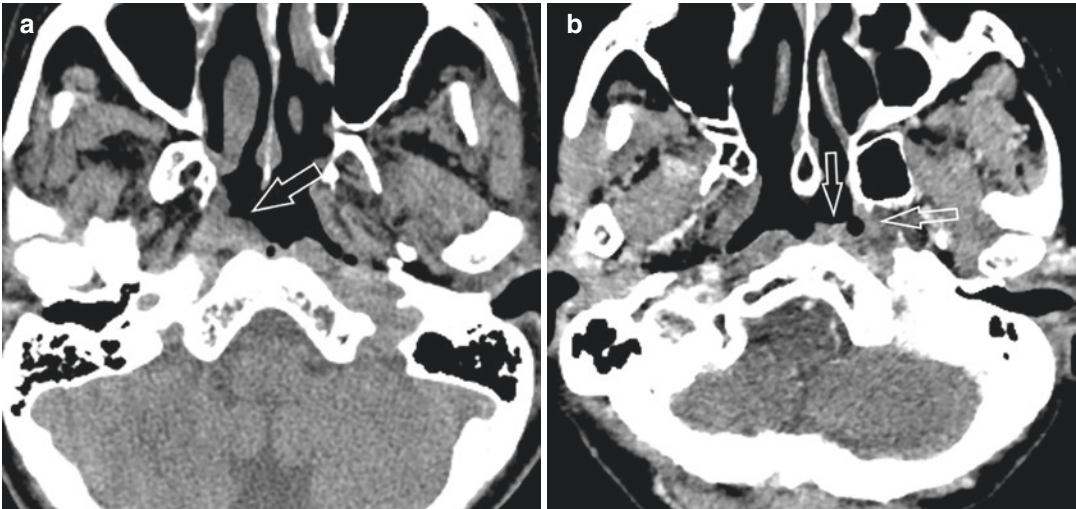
Nasopharyngeal tuberculosis (diffuse mucosal thickening type) in two different patients. (a) Axial unenhanced CT image shows mucosal thickening at right posterior and lateral wall of nasopharynx (open arrow). (b)
